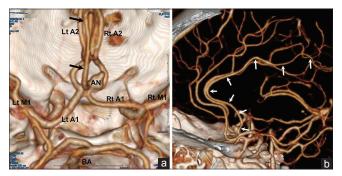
(a) Preoperative three-dimensional CT angiogram, superoinferior view, showing a saccular aneurysm (AN) arising from the trifurcation of the accessory ACA (black arrows), the branching point of the ACoA with fenestration, and the right AI or A2 segment of the ACoA.Aneurysmal fundus projects superolaterally to the right. Lt:left; Rt:right; BA:basilar artery. (b) Left lateral view of the three-dimensional CT angiogram, showing the accessory ACA (white arrows) arising from the posterior surface of the ACoA and running around the genu of the corpus callosum, parallel to bilateral pericallosal arteries, which distributed branches to the medial frontal lobes
